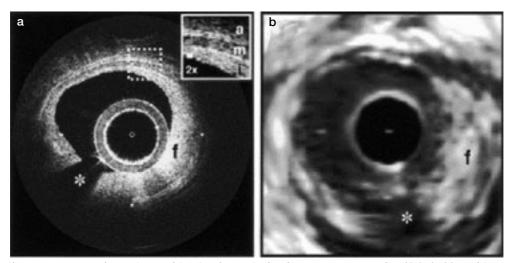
Fibrous coronary plaque imaged in vivo by optical coherence tomography (OCT) (a) and intravascular ultrasound (IVUS) (b). (a) From 9 o'clock to 2 o'clock, this OCT image demonstrates visualization of the intima (with intimal hyperplasia [i]), media (m) and adventitia (a). The internal and external elastic laminae are visible as signal-rich lines bordering the media (inset). A plaque extending from 2 o'clock to 9 o'clock contains a homogeneous, signal-rich region consistent with fibrous plaque (f) that is partially obscured by a guidewire shadow artifact (*). (b) In the corresponding IVUS image, the fibrous plaque (f) is also visualized. Tick marks, 1 mm. (From Reference 27, reprinted with permission; Courtesy : Stuart L. Houser, MD)
